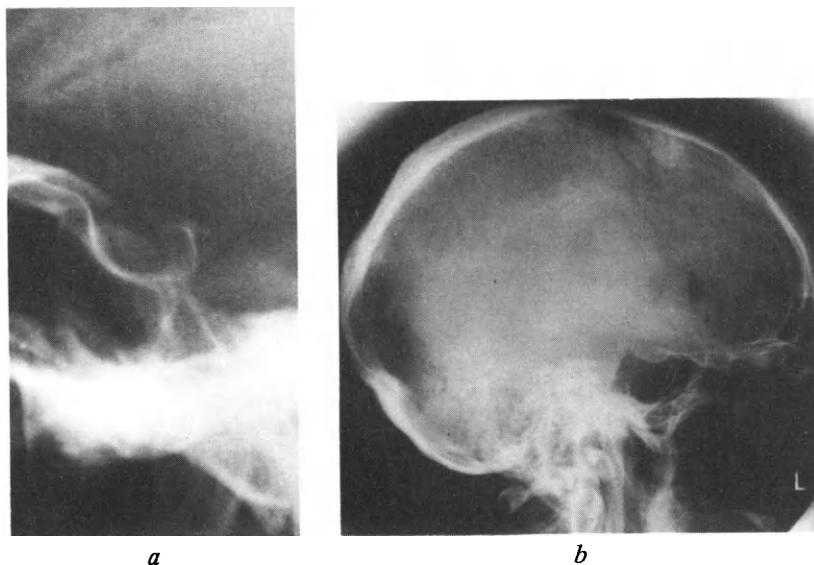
Plain films in two cases of craniopharyngioma. In (a) a coned view of the sella reveals a dorsum which could be thought abnormal. In (b) the gross flattening of the dorsum and downward pressing of the anterior clinoid with opening out of the sella is more typical. In neither case is the deformity completely diagnostic of craniopharyngioma.
